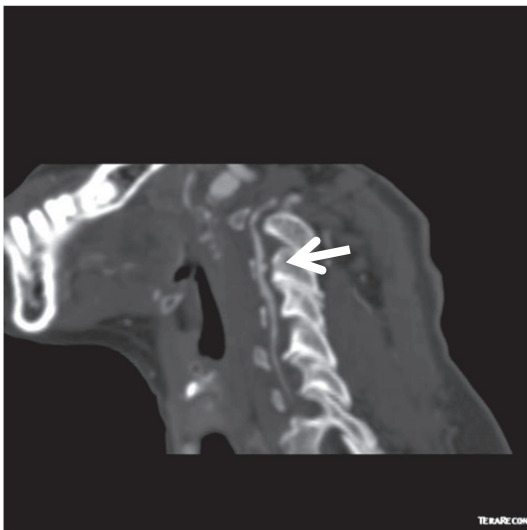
Curved reformatted image from CT angiogram demonstrates irregularity and narrowing of the mid cervical left vertebral artery, reconstituted at the C6 level with small pseudoaneurysm (arrow) projecting posteriorly at the C3 level. Findings are consistent with arterial dissection.
